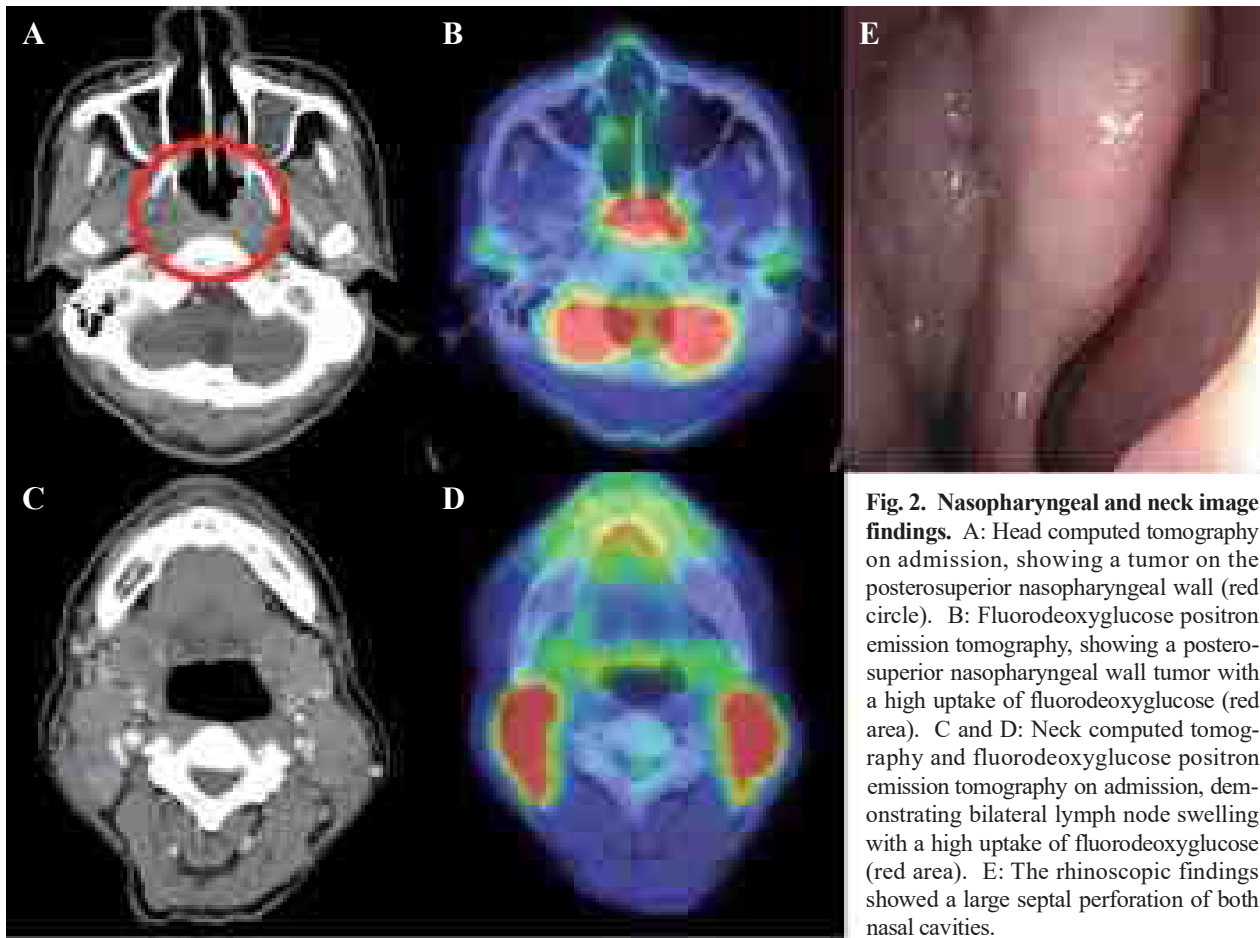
Nasopharyngeal and neck image findings. A: Head computed tomography on admission, showing a tumor on the posterosuperior nasopharyngeal wall (red circle). B: Fluorodeoxyglucose positron emission tomography, showing a posterosuperior nasopharyngeal wall tumor with a high uptake of fluorodeoxyglucose (red area). C and D: Neck computed tomography and fluorodeoxyglucose positron emission tomography on admission, demonstrating bilateral lymph node swelling with a high uptake of fluorodeoxyglucose (red area). E: The rhinoscopic findings showed a large septal perforation of both nasal cavities.
